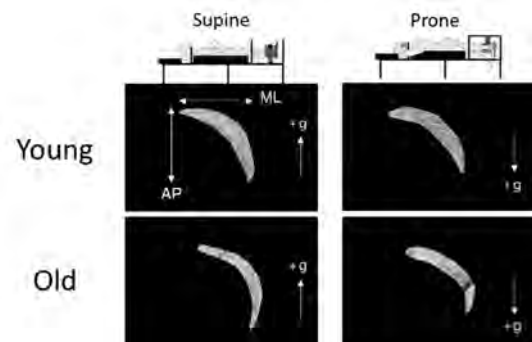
Example ultrasound B-mode images of MG for young (upper) and old adults (bottom) obtained by 3D ultrasound technique in the supine (left) and prone (right) positions.
